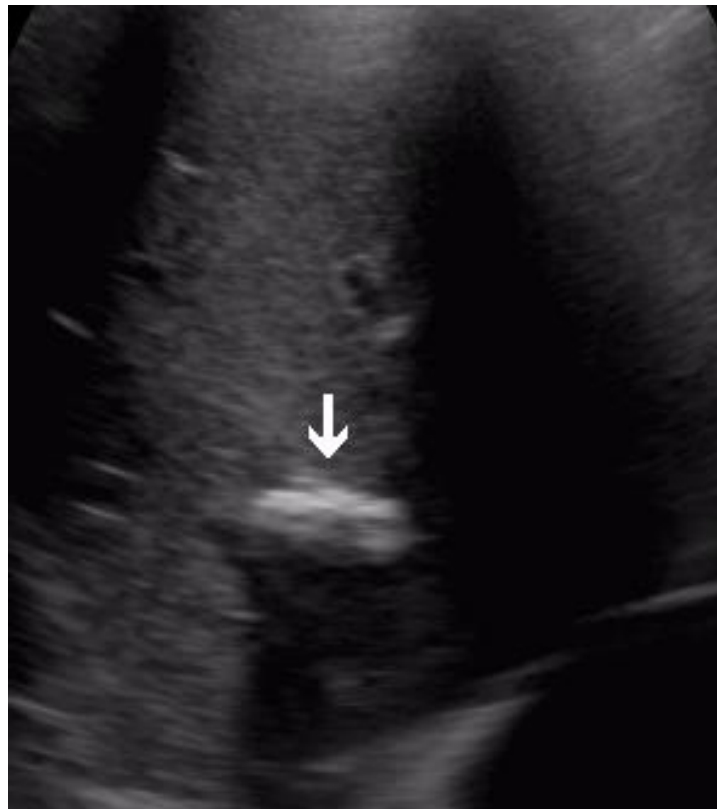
Ultrasound visualization of a bullet in the right part of the liver in the form of a hyperechoic linear formation with an acoustic shadow (arrow).
